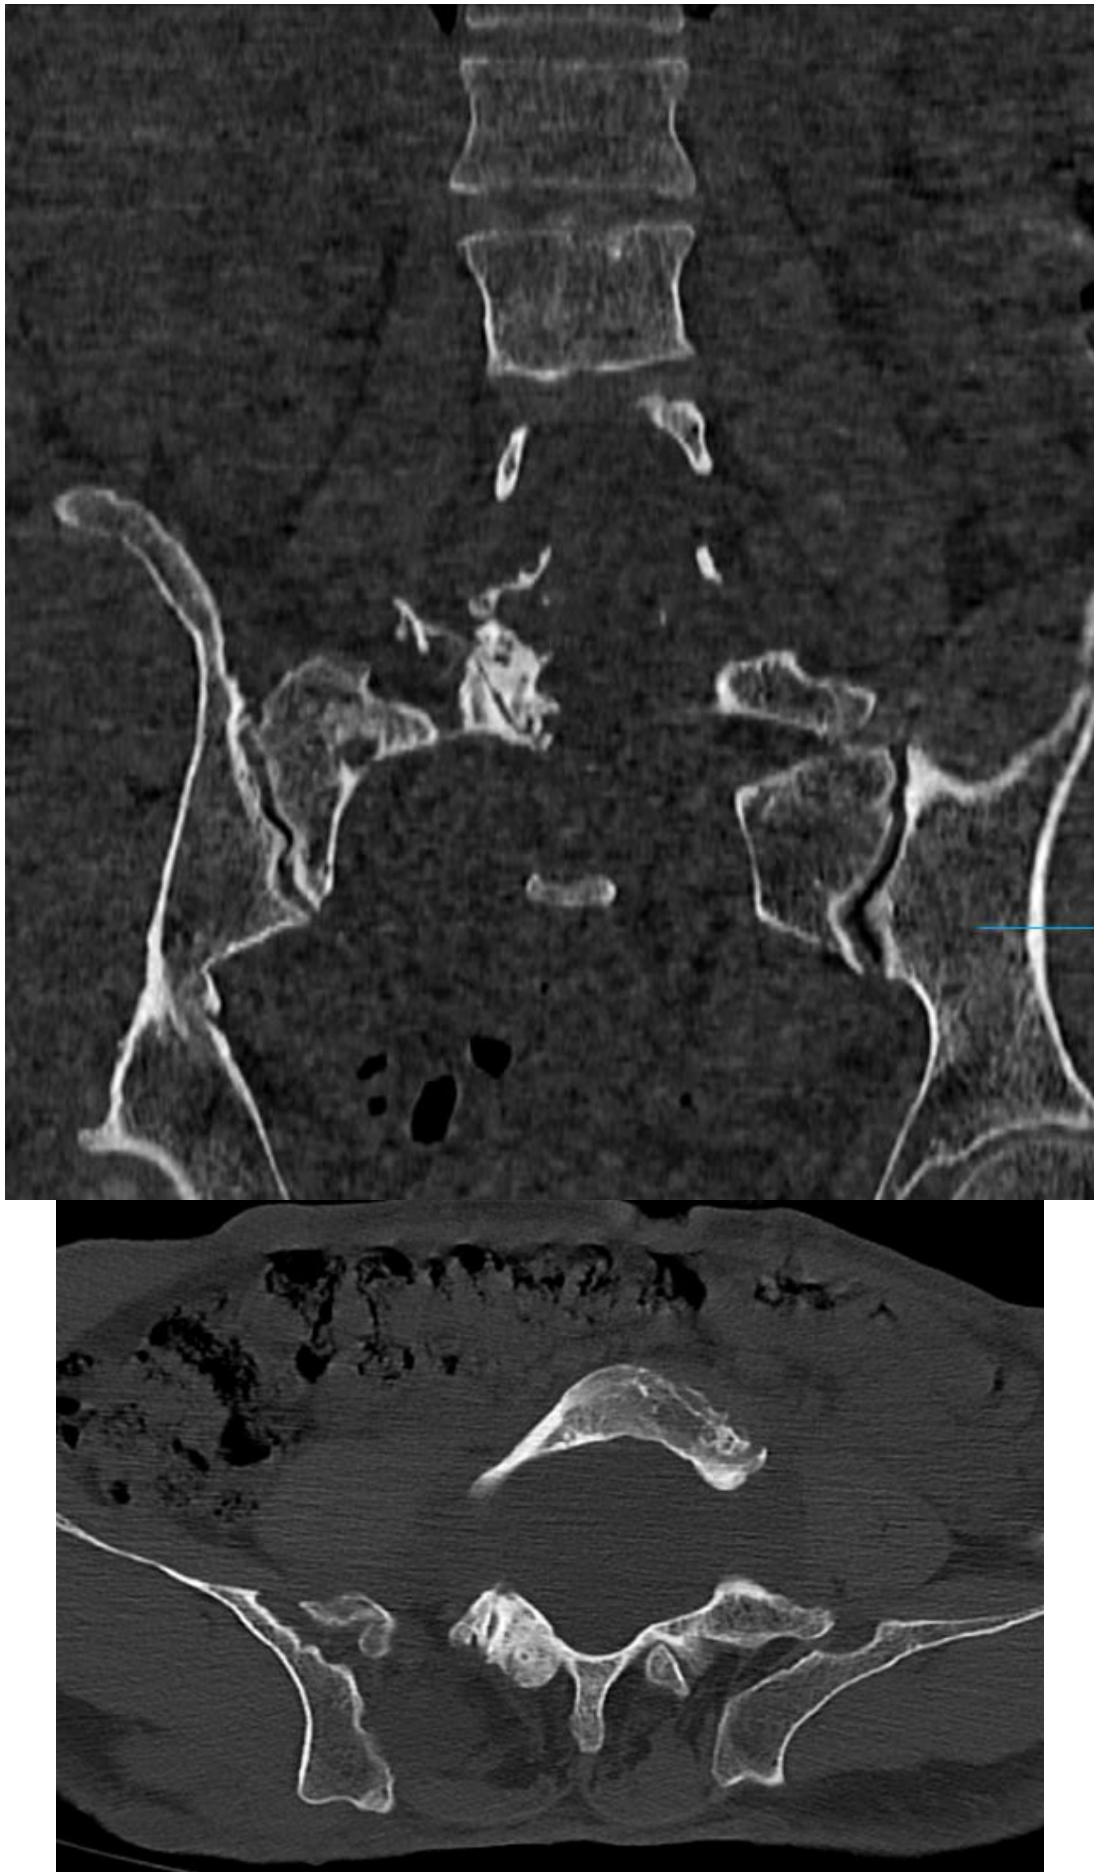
Coronal CT of the lumbosacral spine demonstrating extensive dysplastic remodeling of the lower lumbar and sacral vertebrae with posterior vertebral scalloping, widened sacral neural foramina, and associated meningocele.
